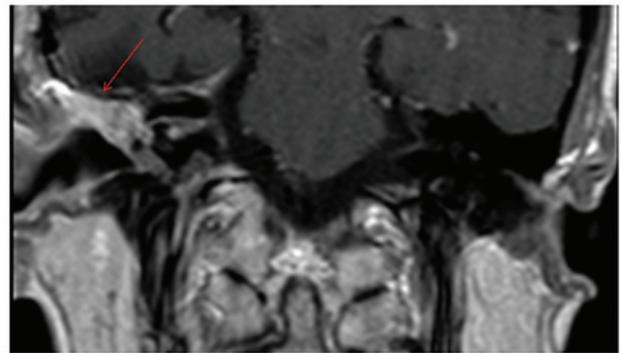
Early post-operative brain magnetic resonance imaging with gadolinium revealing the absence of the intratympanic mass in January 2010. The arrow indicates the area from which the intratympanic mass was removed.
